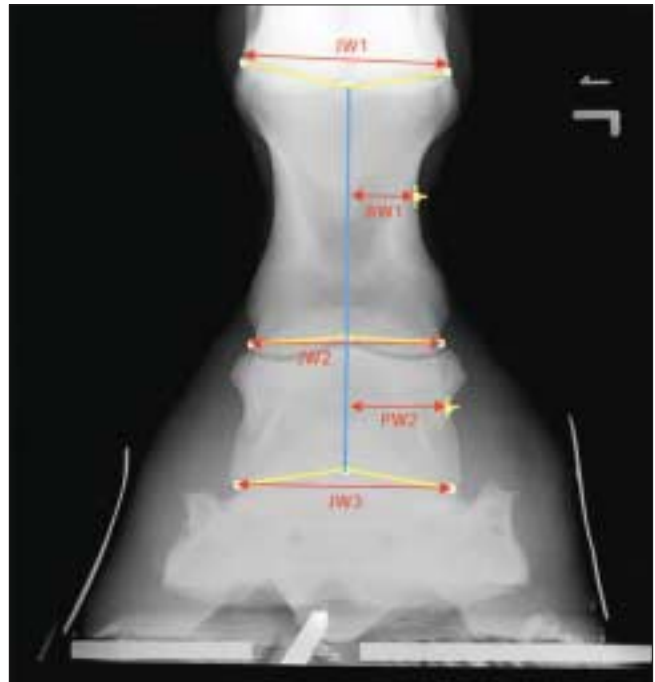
Bone parameters of a dorsopalmar radiograph. JW1: Metacarpal—P1 joint width. JW2: P1-P2 Joint width. JW3: P2-P3 joint width. The width of the joint is the distance between the most medial and lateral aspects of each joint. BW1: P1 Bone Width. BW2: P2 Bone width. The width of the P1 and P2 bones is the value for the distance from the “axis” of the bone (blue line) to the narrowest part of the bone as seen from this view.
